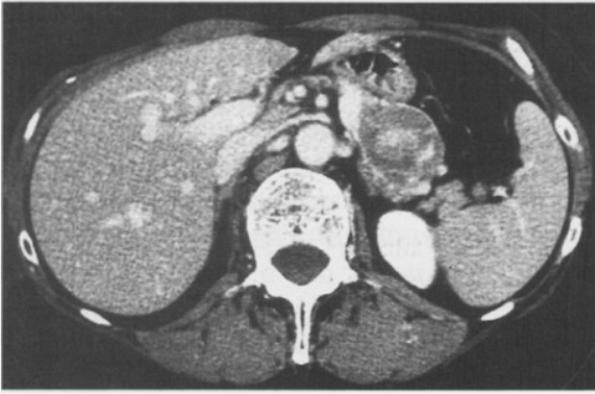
Computed tomography. Presence of a well-defined solid mass in the tail of the pancreas, contiguous with the splenic vein. The mass shows marked contrast-enhancement in the early phase and it is disomogeneous with an hyperdense capsule.
